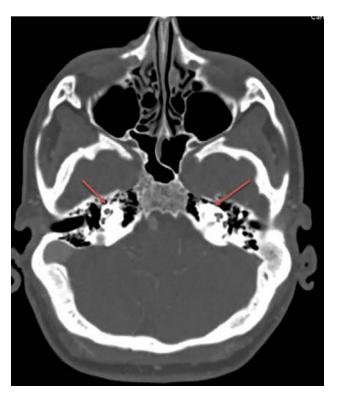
Empty petrous carotid canals. Axial CT angiogram at the level of the petrous portions of the carotid canals demonstrates absence of carotid canals within the expected portions of temporal bones on both sides (red arrows). The finding favors absence of internal carotid arteries (ICA). (Color version of figure is available online.)
